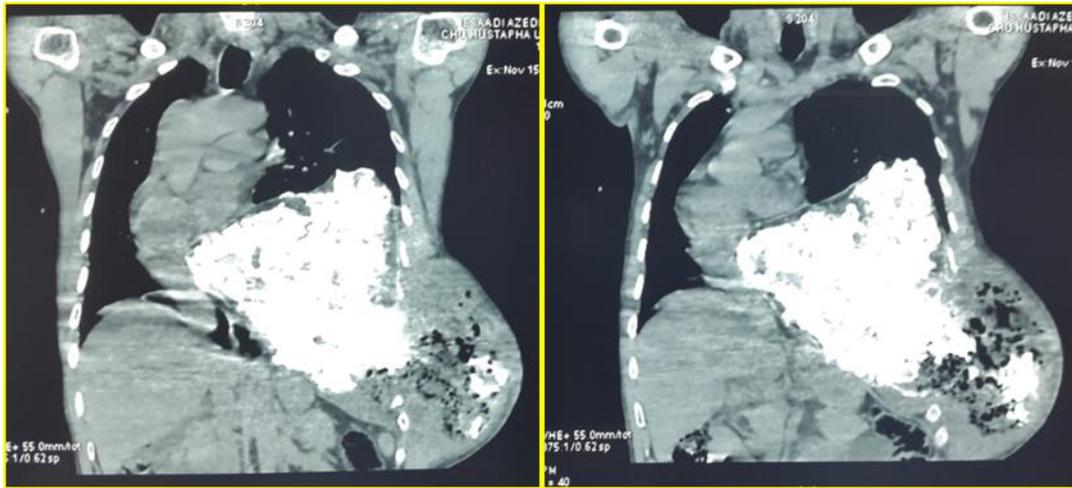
Thoracic CT: Expansive Process of the 8th left side
